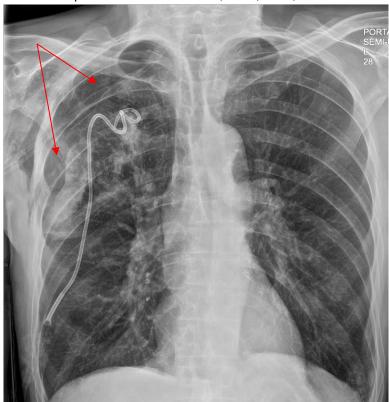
Chest X-ray showing a right-sided pneumothorax [arrows], managed by an 8-French drainage catheter.
